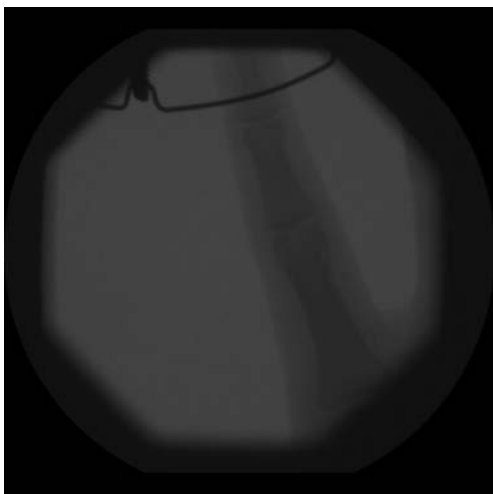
Post-reduction x-ray (with traction)
